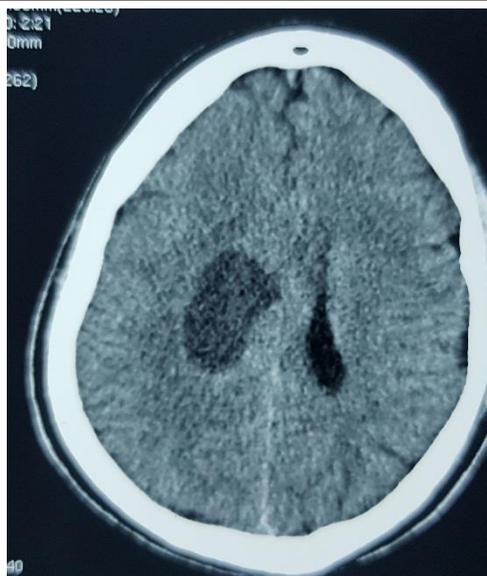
CT -brain showed dilated right lateral ventricle
